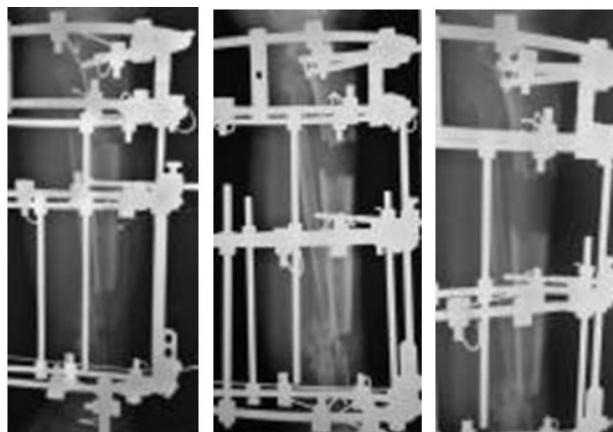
Plain radiograph post op, 1 month and during docking
